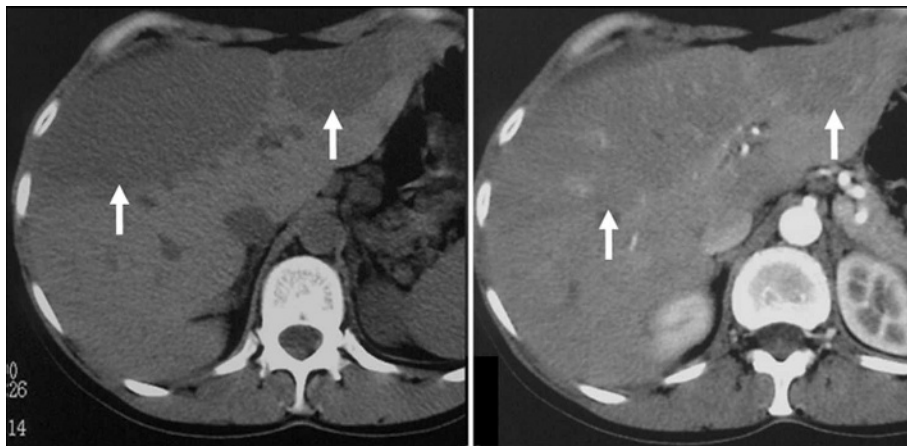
Direct (A) and iodinated (B) spiral computed tomography scans revealed regular polycyclic borders area (white arrows), hypodense compared with remaining parenchyma, with no mass effect and/or any displacement of the parenchymal vessels.
